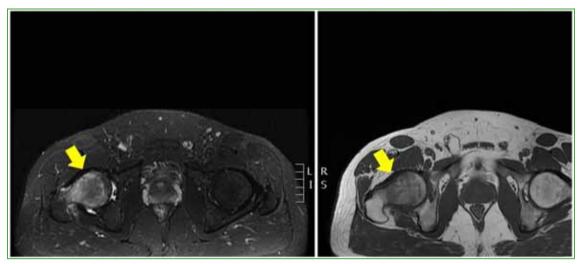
MRI T1-weighted and T2-weighted axial sequences. The right femoral head and neck show high signal intensity in T2-weighted sequences and low signal intensity in T1-weighted sequences, suggesting bone edema. Furthermore, there is joint effusion in the right hip; joint space is preserved.
